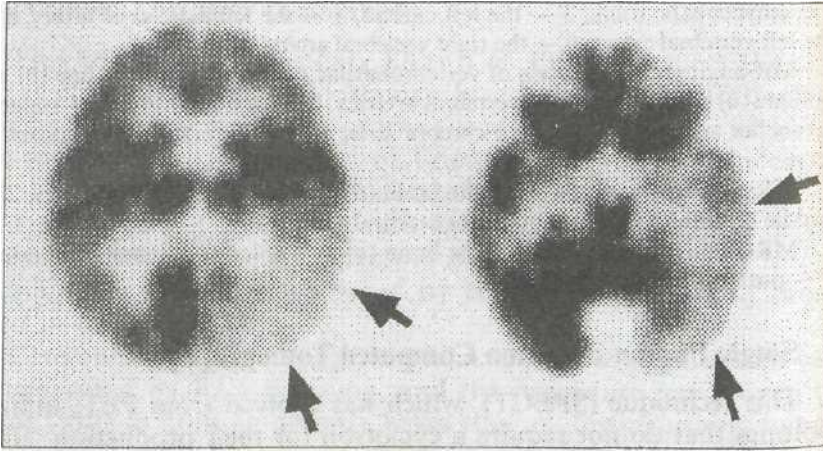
PET. Typical parieto-occipito-temporal distribution (arrows) of hypometabolism seen with positron emission tomography using ^{18}F -fluorodeoxy-glucose, in a patient with normal findings on magnetic resonance imaging. The darker areas represent higher metabolic rates
